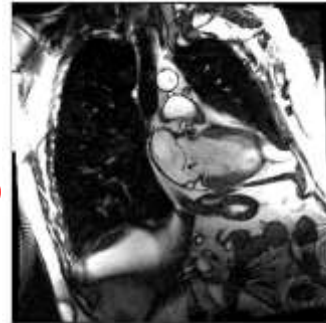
Magnetic resonance imaging of the heart showing mitral regurgitation (arrow) with posterior flow (black arrow) between the anterior and posterior chambers of the heart.
